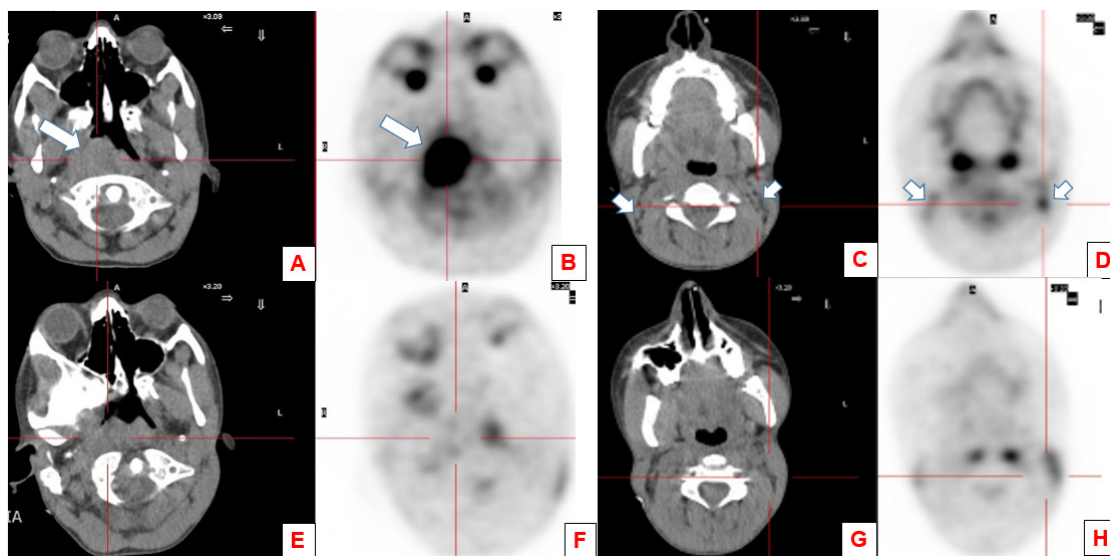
In addition to contrast-enhanced (CE) computed tomography (CT) and head and neck magnetic resonance imaging (MRI), the patient underwent a ^{18}F -fluorodeoxyglucose positron emission tomography/CT (^{18}F -FDG PET/CT) scan for local staging of nasopharyngeal carcinoma (NPC). PET/CT scans were acquired on an integrated PET/CT scanner (Discovery ST, General Electric Medical System, Milwaukee, WI, USA). The lesion identified on the CT component (white arrow, A) of the PET/CT scanner demonstrated anterior extension toward the septum and involvement of the retropharyngeal and prevertebral regions. PET/CT scan demonstrated increased ^{18}F -FDG uptake [maximum standardized uptake value (SUV_{max}): 14.3] (white arrow, B) within a solid right-sided mass. The mass had a maximum diameter of 47 mm on the axial plane and was located in the right vault wall of the nasopharynx. In addition, bilateral ^{18}F -FDG-avid (SUV_{max} : 7.5) superior jugular lymph nodes (white arrows, C, D), suspected for metastatic lesions, were noted. The child underwent three courses of induction chemotherapy (cisplatin/5-fluorouracil) and a further PET/CT scan, which demonstrated decreased size and uptake of the nasopharyngeal mass (E, F) and lymph nodes (G, H). Subsequently, the patient underwent radiotherapy (64.8 Gy) with concomitant chemotherapy.
